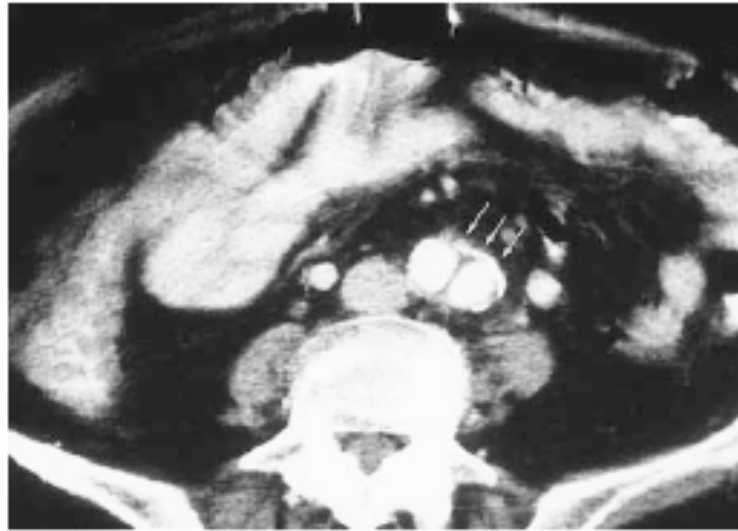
Normal perigraft ring. CT scan shows perigraft tissues that are no more than 5 mm thick (arrows).
